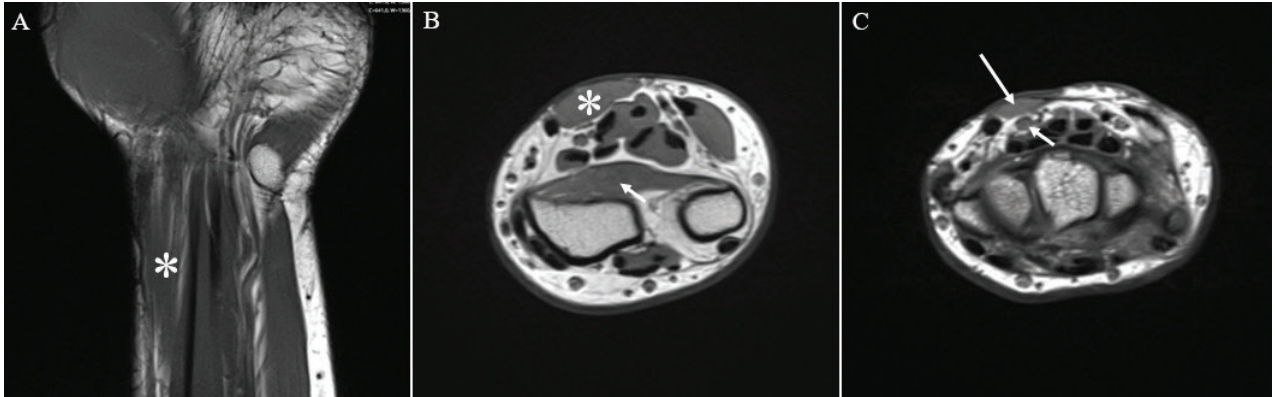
(A) Coronal T1-weighted MRI of the left distal forearm and wrist showing a hypertrophied muscle belly of a reversed palmaris longus (asterisk) located superficially in the distal forearm. (B) Axial T1-weighted MRI at the distal forearm level demonstrating the muscle belly of the reversed palmaris longus (asterisk) located superficially, with the pronator quadratus muscle (arrow) visible in its typical deep position adjacent to the distal radius, serving as an anatomical reference for distal forearm level. (C) Axial T1-weighted MRI at the proximal third of the carpal tunnel showing the muscle belly of the reversed palmaris longus (long arrow) positioned superficially and in close anatomical proximity to the median nerve (short arrow).
